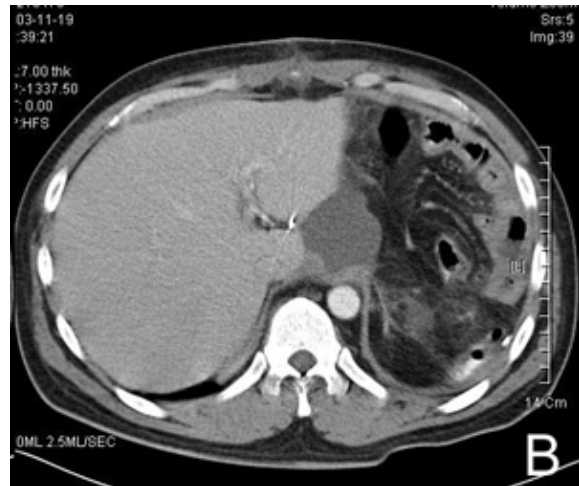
CT scan on the lower level reveals fluid collection in the perihepatic space, adjacent to the caudate lobe.
